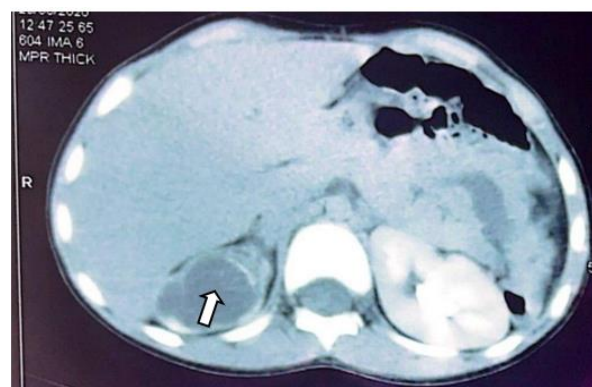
CT-scan image showing a right renal hydatid cyst
